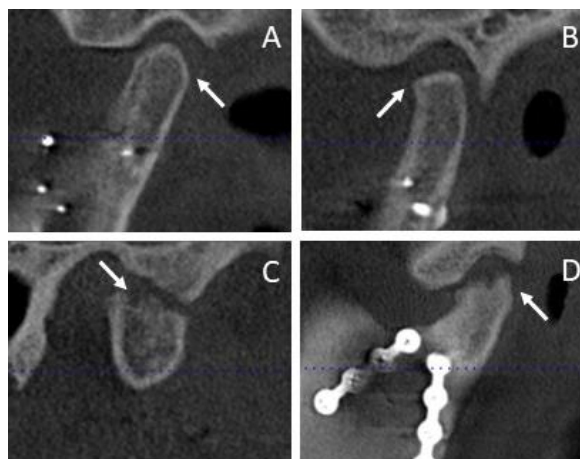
Sagittal CT views of condyles. Representing examples of osseous changes observed, and corresponding osteoarthritis (OA) diagnoses. A. No osteoarthritic condyles, rounded condylar head, and well-defined cortical margin. B. Indeterminate for OA, flattened superior margin, and well-defined cortical margin. C. OA: surface erosion. D. OA: surface erosion and sclerosis.
